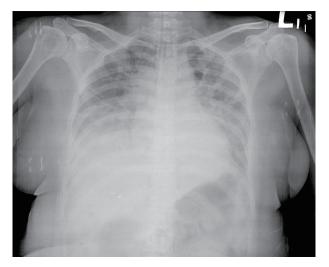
Postoperative chest x-ray taken at the arrival of the intensive care unit reveals increased interstitial opacity throughout bilateral lung.
